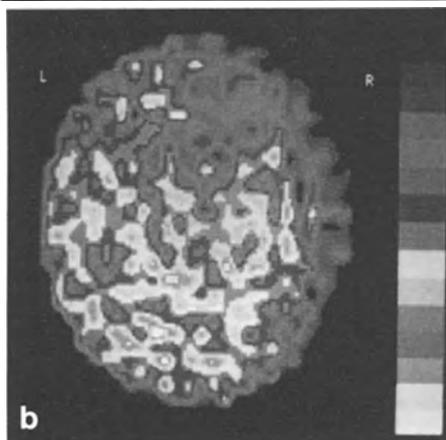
a CT scan after contrast enhancement in a 49-year-old man hospitalized with general seizures. The CT scan demonstrates a right frontal glioblastoma with a large area of central necrosis and a small solid tumor rim. b The blood flow measurement of the tumor with HIPDM SPECT shows a decreased tracer uptake (hypoperfusion) in the necrotic area, visible as a dark region. The small solid tumor rim is not detectable with SPECT
